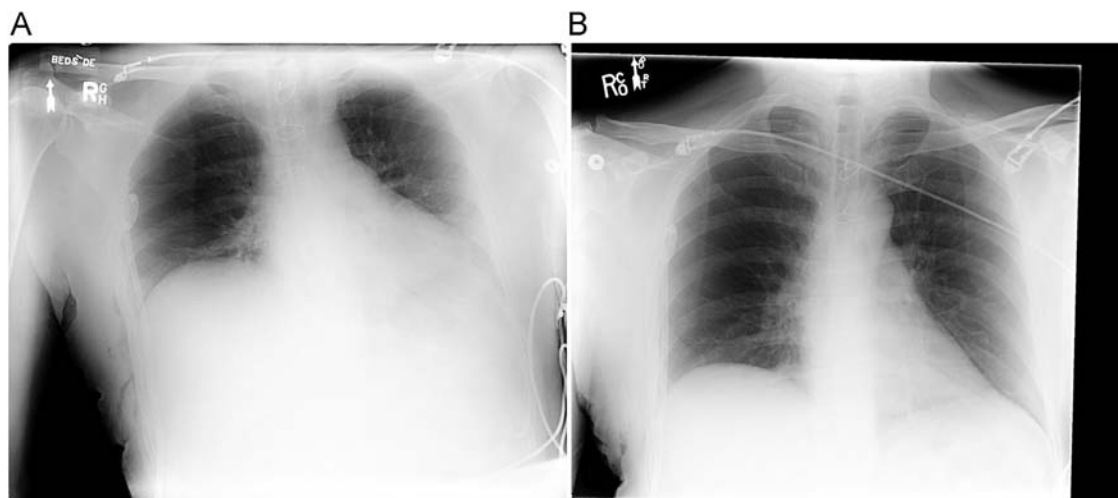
An anterior-posterior chest radiograph series of the patient with pain and dyspnea after a video-assisted thoracic surgical excision of a right-sided mass taken (A) before and (B) after an erector spinae plane block.
